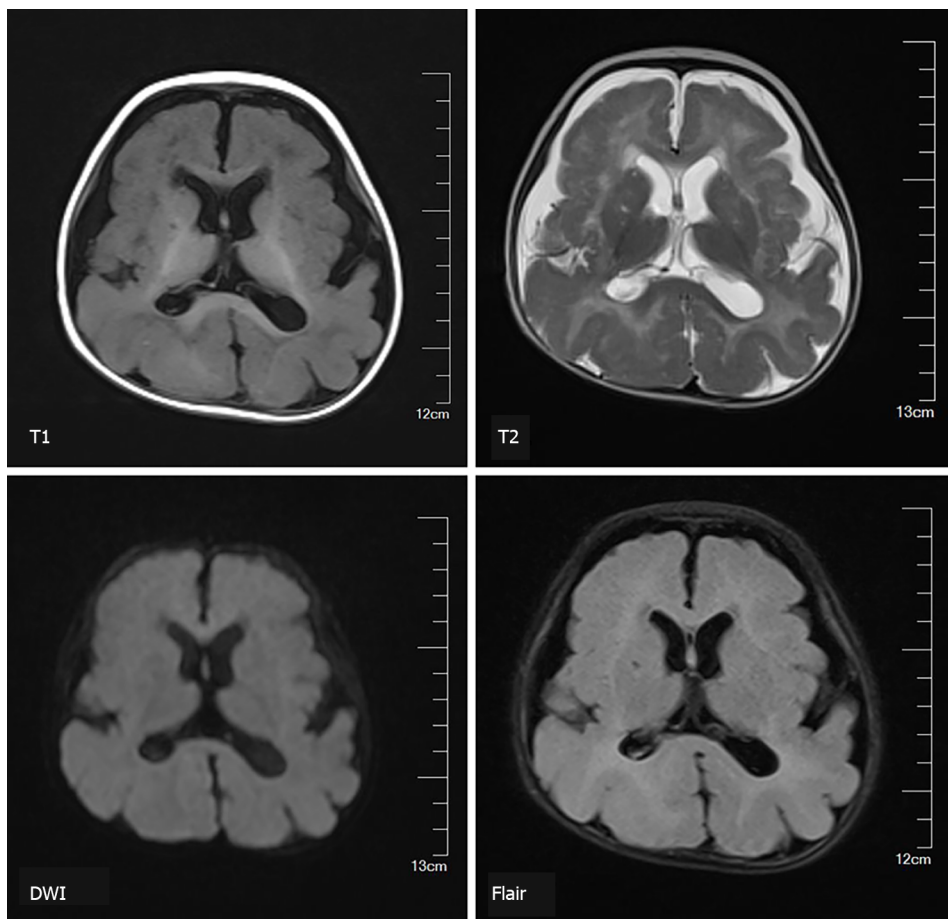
Brain magnetic resonance imaging of the proband revealed a simple brain structure, with widened and thickened gyri and shallow sulci.
